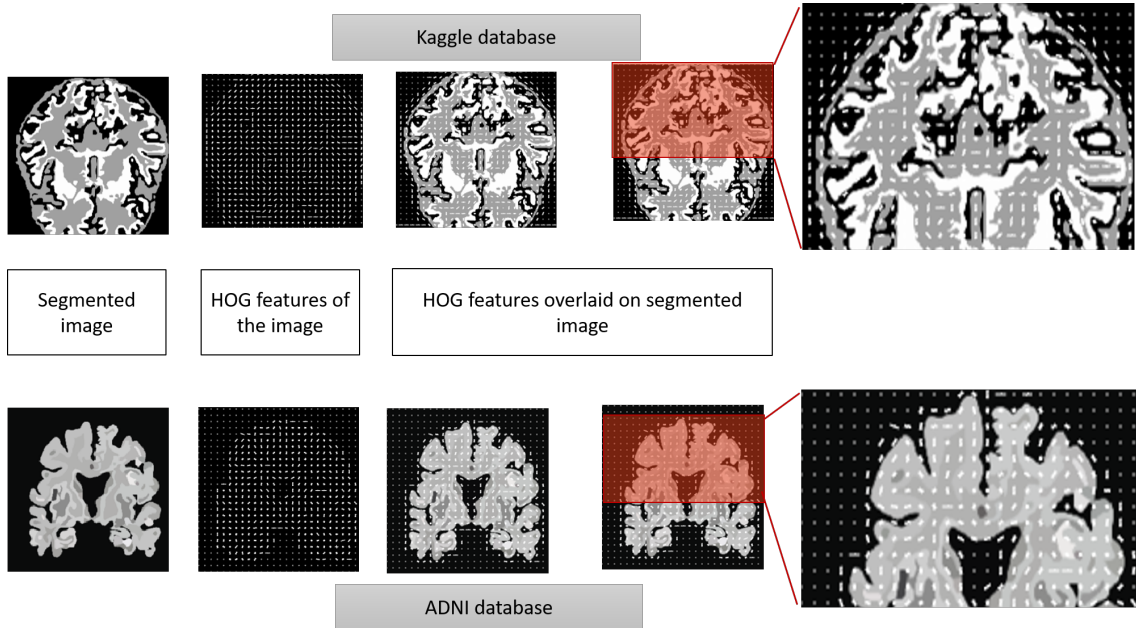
Results of the HOG feature representation on the segmented MRI brain images using BCFCM.
